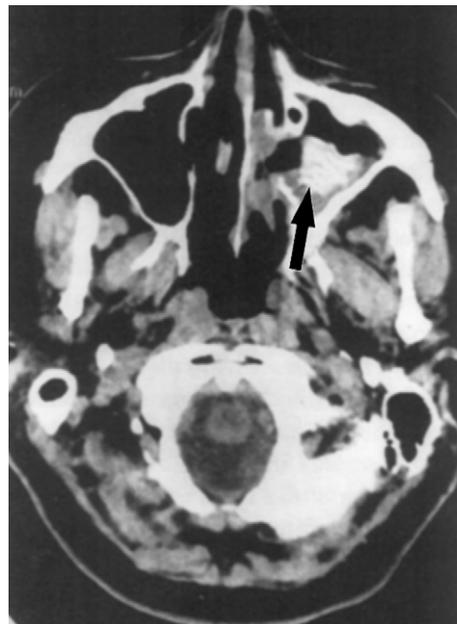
Aspergillus* fungus ball. Axial CT scan through the maxillary sinuses shows a calcified fungus ball (arrow) in the left maxillary sinus. The thicker walls of the left maxillary sinus are indicative of chronic inflammatory disease.
